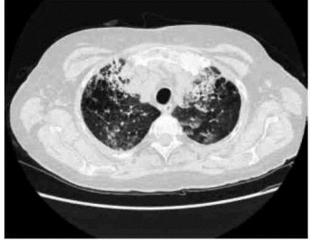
HRCT-massive interstitial densities in both lungs, pulmonary hemorrhage picture
